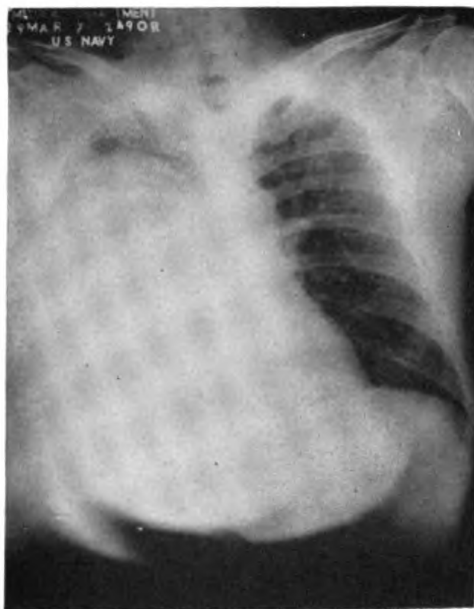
Case 1. Roentgenogram taken prior to treatment. The large fluid collection in the right hemithorax is easily demonstrable.
